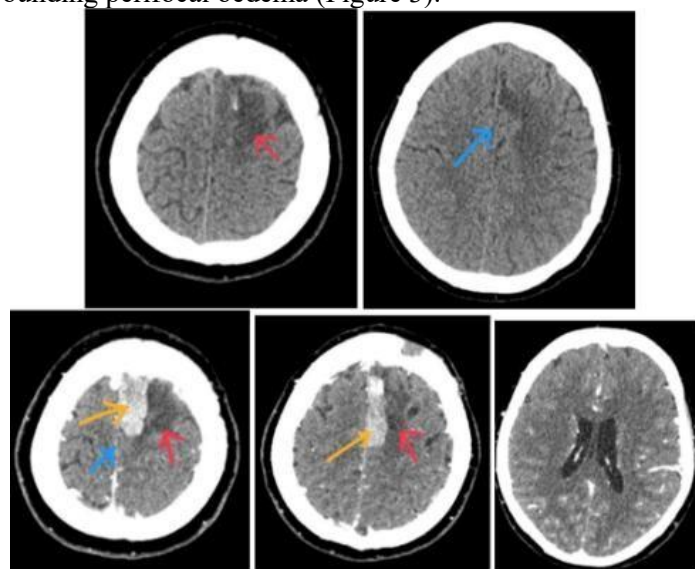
Head CT scan with contrast post-craniotomy (blue arrow: midline in the center; yellow arrow: tumour lesion; red arrow: perifocal edema).
